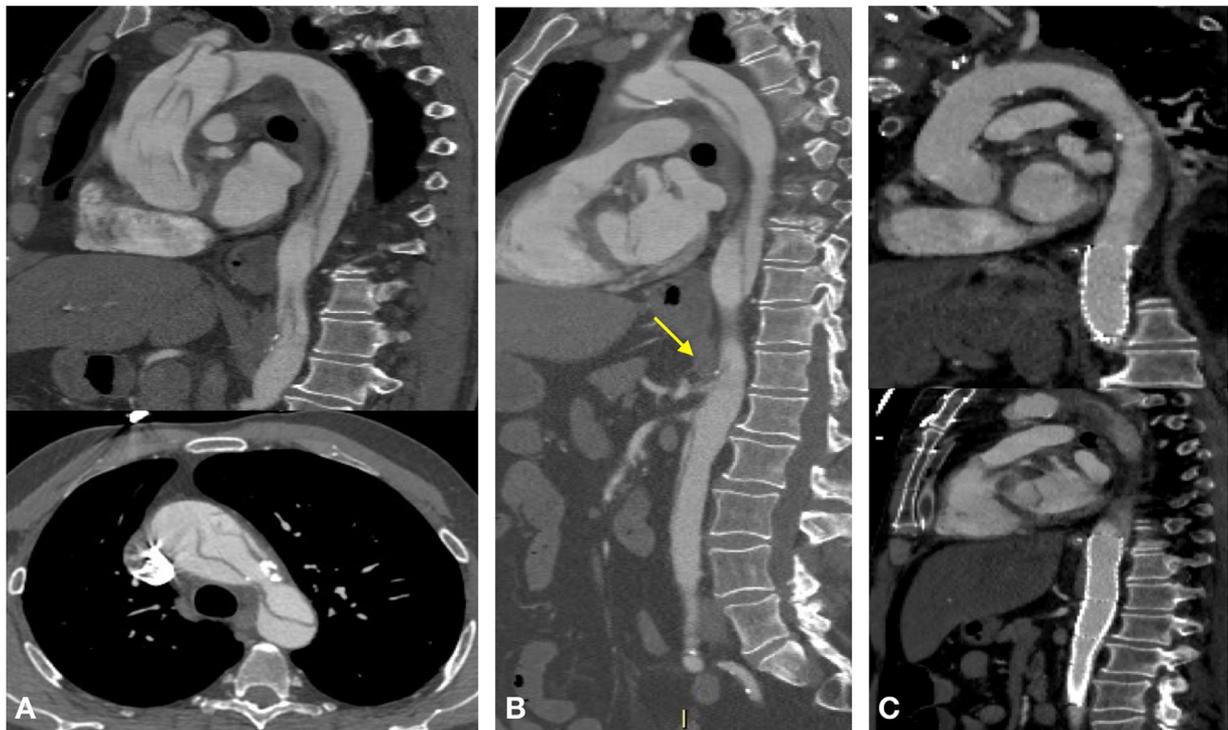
Patients with acute type A dissection. Presented in our department with abdominal pain and melena (A). True lumen compression at the CT scan (arrow B). The treatment option consisted in stent positioning followed by hemiarch replacement (C).
